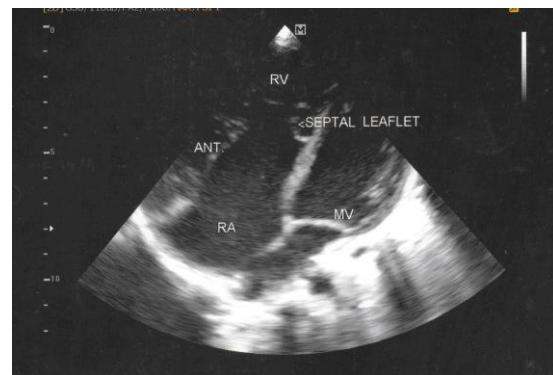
Echocardiogram showing Ebstein's anomaly (apical displacement) of the tricuspid valve with long anterior leaflet and rudimentary septal leaflet (Arrowed) and formation of an “Atrialized” Right Ventricle (ARV)
